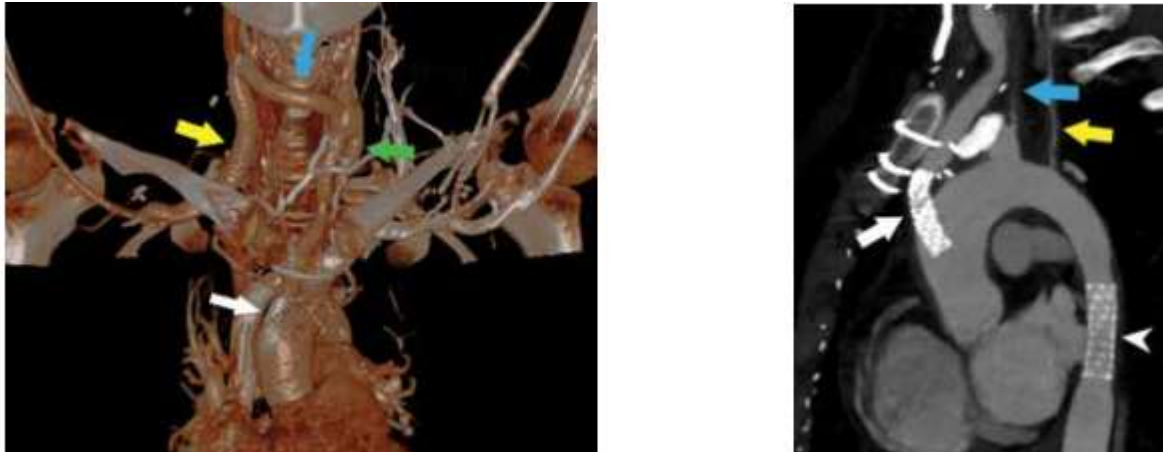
A. CT angiography in patients with Takayasu's arteritis type II. B; sub-occlusive stenosis ACCS, occlusion ASS, sub-occlusion ACD Condition after implantation of conductor between ascending aorta and left ACCS with stent placement at stenosis site (white arrow), by-pass between left ACCS and left axillary artery (green arrow), between ACCS and ACDx (blue arrow) and after implantation of a conductor between the right subclavian artery and the right ACC (yellow arrow). B. Multiplanar reconstruction of CT angiography in patients with Takayasu's arteritis type II. B with stent placed in conductor stenosis between ascending aorta and left ACCS (white arrow) and in descending aortic stenosis (arrowhead). Sub-occlusive stenosis of the left ACCs (blue arrow) and left subclavian artery (yellow arrow).
